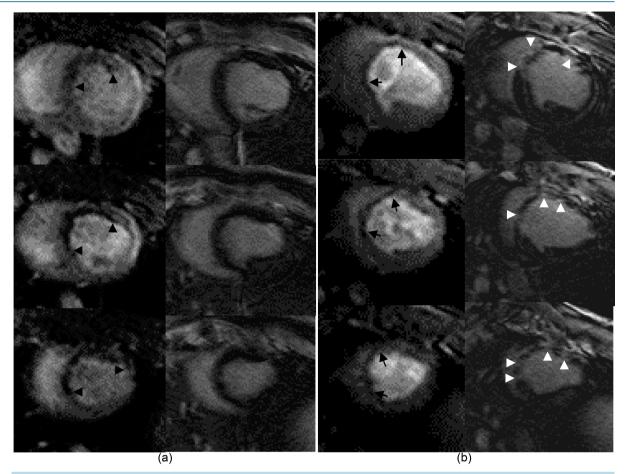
Multislice first pass perfusion DE-MR images acquired 1 hr ((a), left block) and 1 week ((b), right block) after LAD embolization show the persistent perfusion deficit in embolized myocardium. DE-MRI images acquired 1 hr after embolization failed to demonstrate myocardial microinfarct. On the contrary, DE-MRI provided evidence of microinfarct at 1 week.
